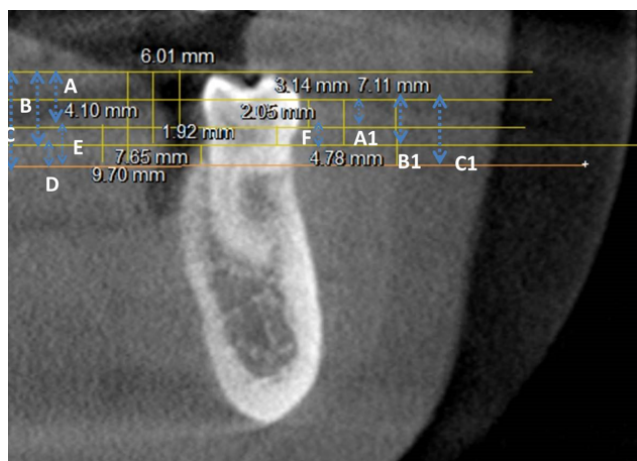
CBCT image of the mandibular molar showing the nine measurements (A, B, C, D, E, F, A1, B1, C1) taken in this study.
